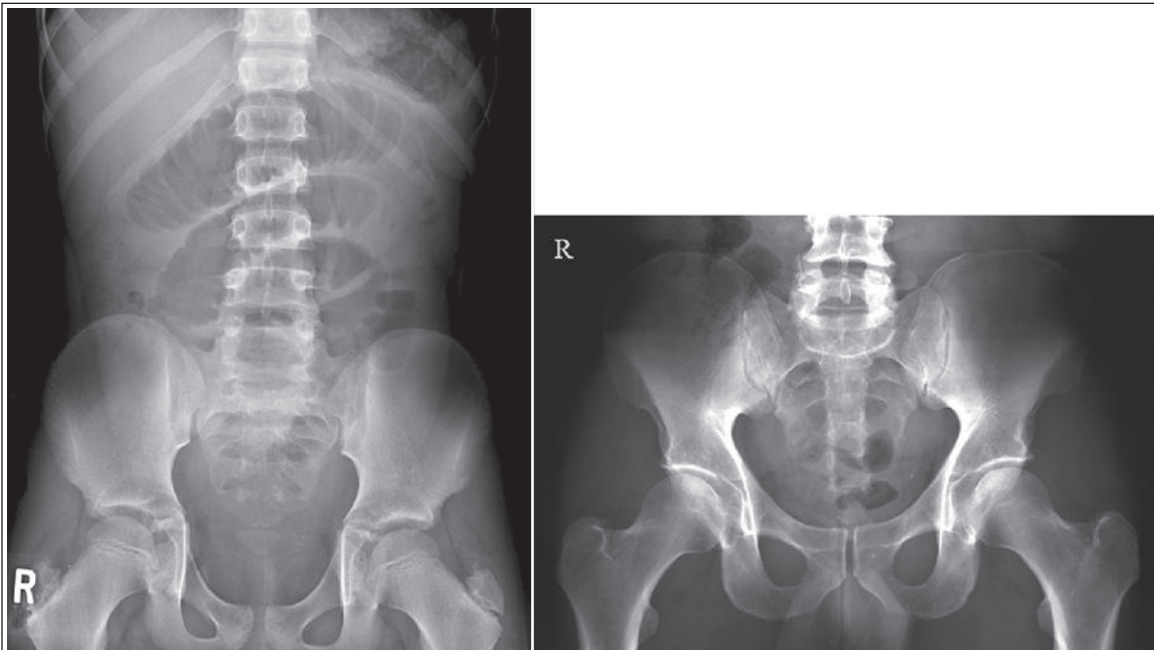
Properly positioned AP abdomen and pelvis projections demonstrating the effect of CR placement. Compare the relationship of the symphysis pubis and coccyx and how differently the sacrum is visualized. Both projections are taken with a perpendicular CR, but the CR is centered to the midsagittal plane at the level of the iliac crest for the abdomen projection and is centered at the inferior sacrum for the pelvis projection. The symphysis pubis and coccyx on both projections were recorded using diverged beams, but because the CR is centered more superiorly and beams with greater angles of divergence were used to record the symphysis pubis and coccyx on the abdomen projection, the symphysis pubis is moved more inferiorly to the coccyx on this projection when compared with its alignment with the coccyx on the pelvis projection. Also compare sacral visualization on these two projections. Because of the more inferior centering used in the pelvis projection, the x-rays recording the sacrum are angled cephalically into the curve of the sacrum and those recording the sacrum for the abdomen projection are angled caudally, against the sacral curve. This results in decreased sacral foreshortening on the pelvis projection and increased sacral foreshortening on the abdomen projection. The off-centered diverged beams will affect structures in the same manner that an angled CR will.
